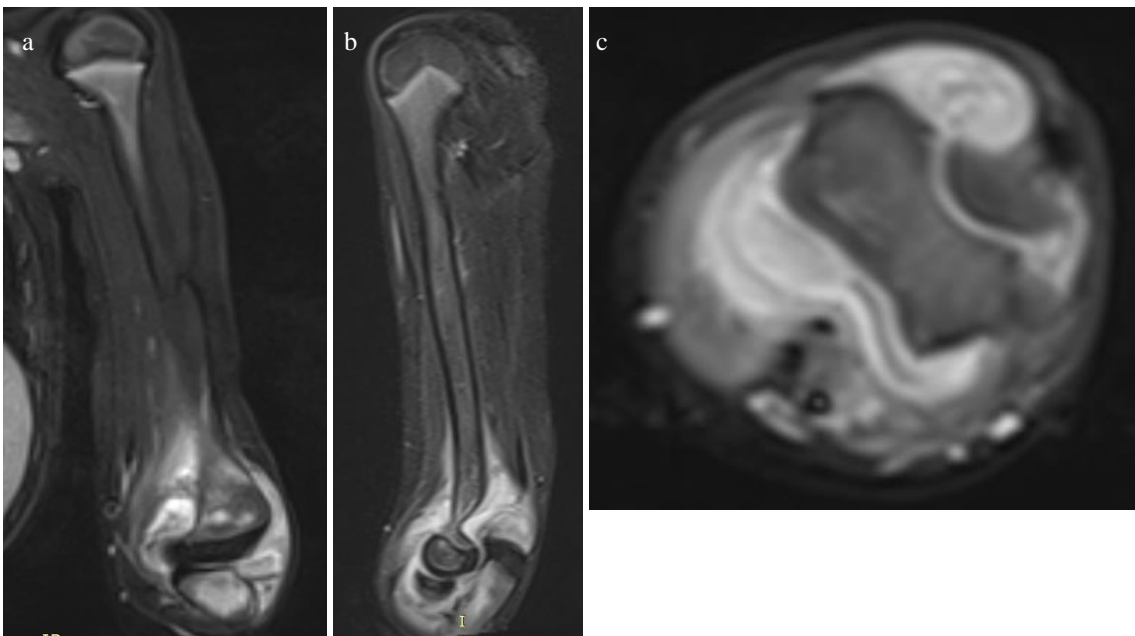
Preoperative MR image of the left elbow of a 7-year-old male patient (patient 5) (a: coronal MR image, b: sagittal MR image, c: axial MR image)
